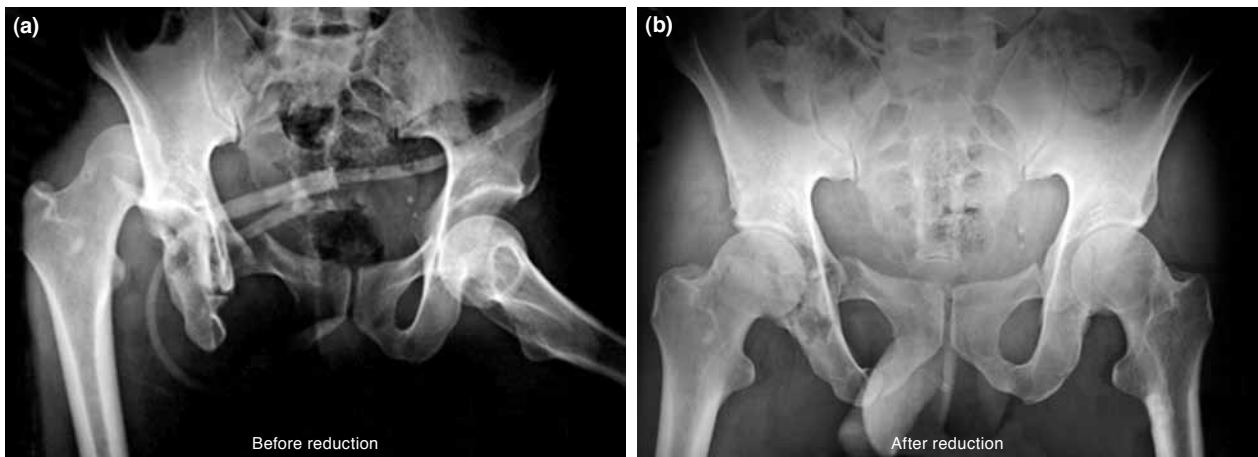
(a) Radiograph in the Emergency Department demonstrated a right-sided comminuted fracture of the acetabulum, fractures of the superior and inferior pubic rami, and posterior dislocation of the hip joint and a left-sided fracture of the superior pubic ramus and anterior dislocation of the hip joint. (b) Satisfactory reduction of both hip joints is noted.
